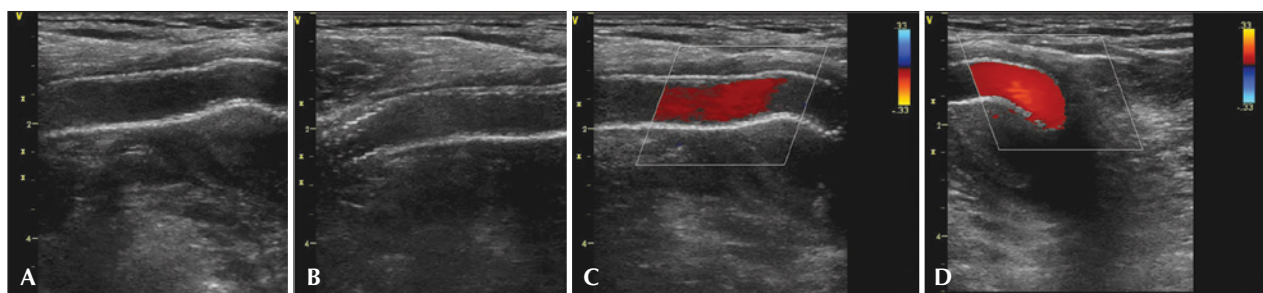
B-mode vascular ultrasound and color ultrasound after implantation. (A) B-mode ultrasound of the endoprosthesis showing no signs of stent fractures. (B) B-mode ultrasound showing the connection of the two overlapping endoprostheses. (C) Color ultrasound showing no signs of stenosis or neointimal hyperplasia. (D) Color ultrasound at the level of the joint region showing its run-off.
